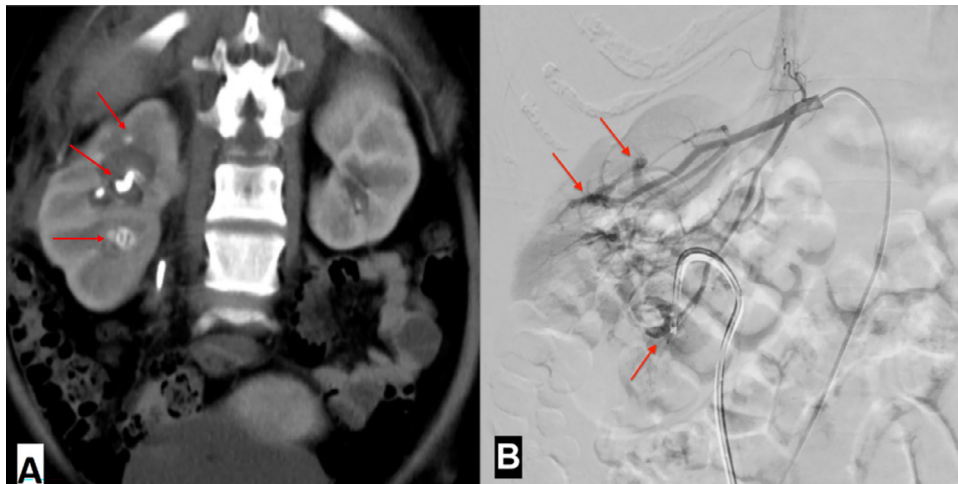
CT scanner and angiography images. (A) Multi-pseudo aneurysms found on CT scanner image (arrows). (B) Renal angiography showed the abnormal appearance of renal vascular perfusion (arrows). More selective angiography (not shown) confirmed they were pseudo aneurysms.
